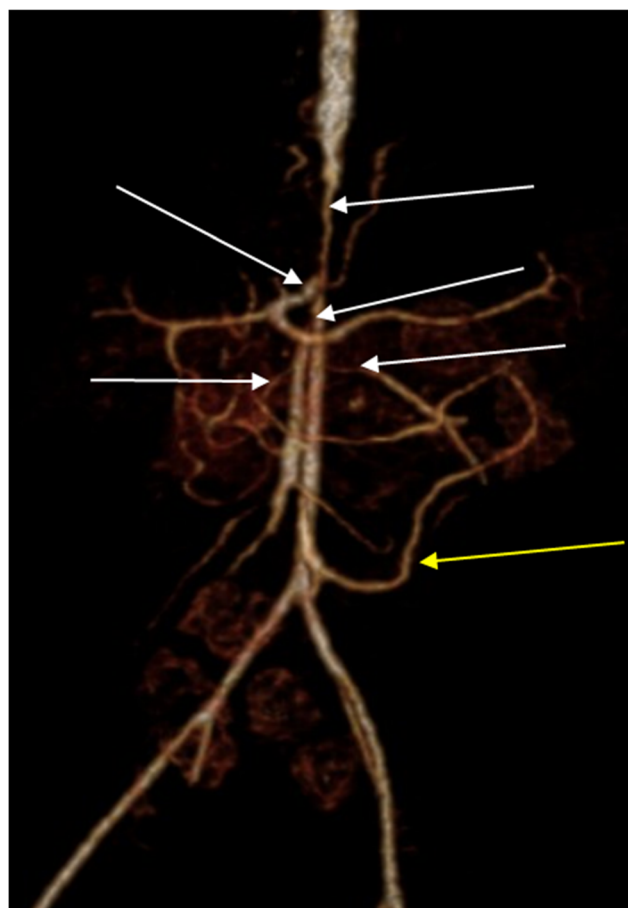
This 3D reconstruction of a CTA abdomen from a 6-year-old female with NF1 shows middle-abdominal aortic stenosis, celiac axis stenosis, superior mesenteric artery stenosis, and bilateral renal artery stenosis (white arrows). An arc of Riolan arising from the inferior mesenteric artery is shown (yellow arrow), indicating collateral revascularization to the foregut
